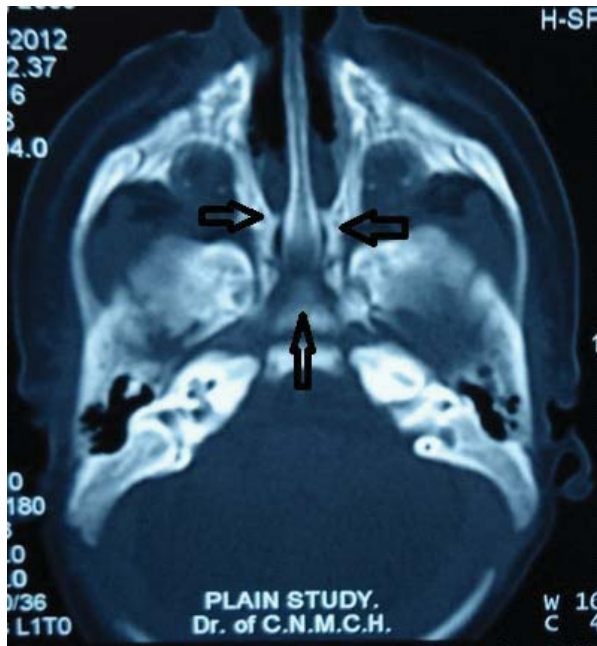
HRCT showing hypertrophy of the posterior end of the Vomer almost abutting with the pterygoid plates of the Sphenoid laterally (shown by horizontal arrows) and the body of the Sphenoid posteriorly (shown by vertical arrow).
